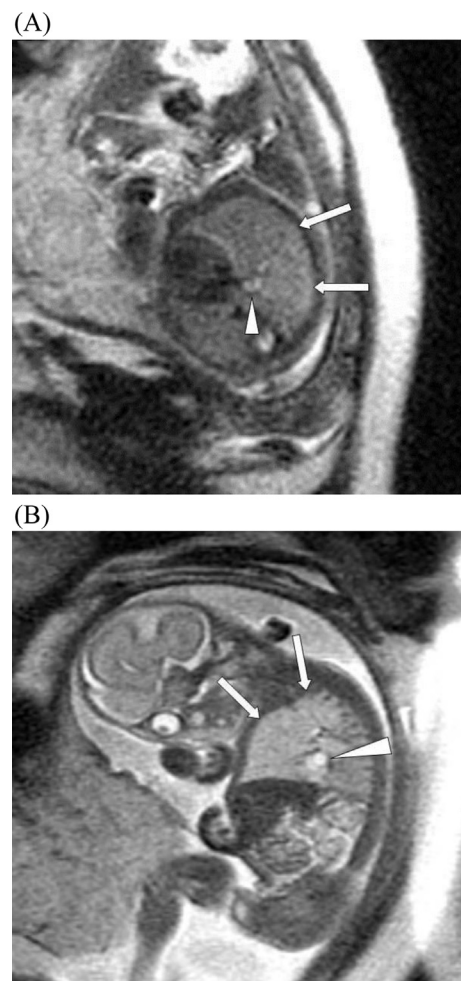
(A) Axial and (B) coronal MRI of CLFO in case 2 at 23 weeks gestational shows hyperintense and expanded right upper lobe (arrows), suggesting fluid overload and causing compression of the heart toward the left (arrowheads).
